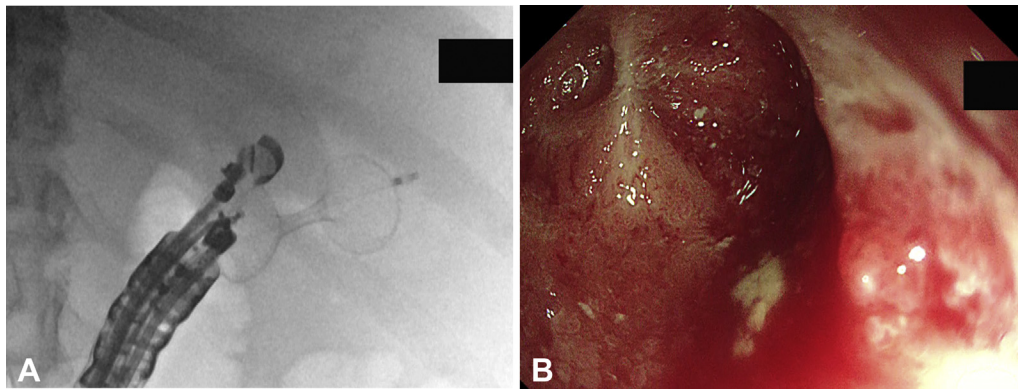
A, Radiographic imaging of EUS-guided gallbladder drainage after stent placement. B, Cholecystoscopic image showing a scarred gallbladder consistent with chronic cholecystitis changes.
